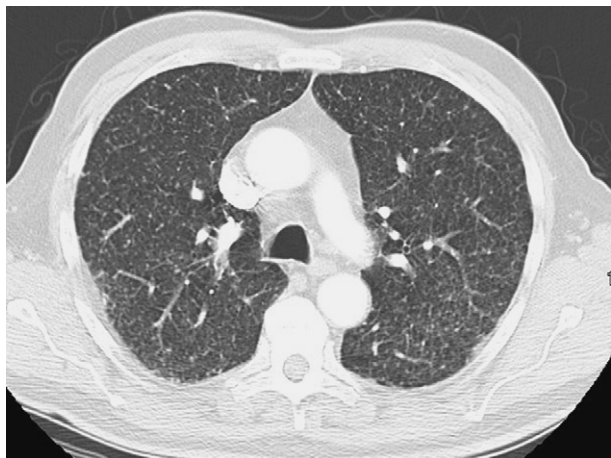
Thoracic CT showing extensive pulmonary nodularity due to disseminated BCG disease. The differential diagnosis of such an appearance would include miliary tuberculosis.
